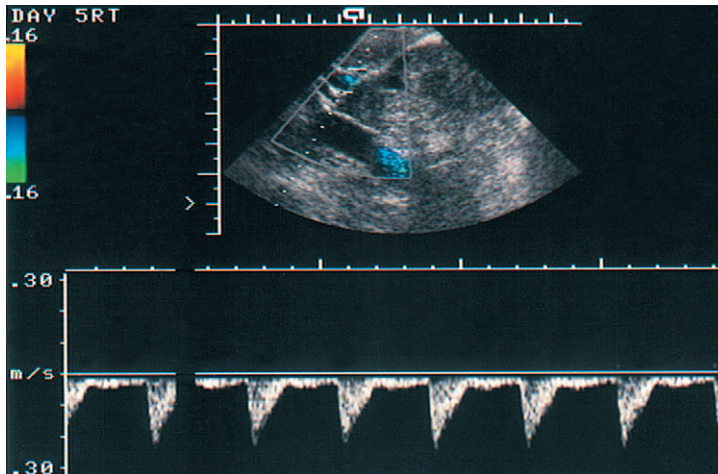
Doppler spectrum of uterine artery blood flow in the luteal phase.
